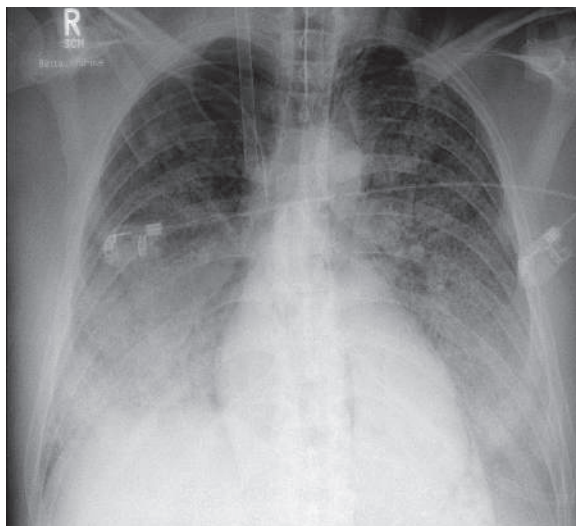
Anteroposterior plain chest radiograph of a Wegner's granulomatosis (WG) patient in the intensive care unit shows bilateral diffuse alveolar lung disease due to pulmonary hemorrhage
